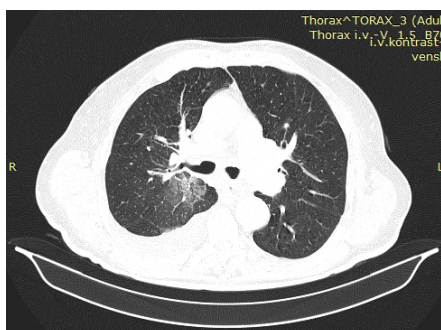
Chest CT in lung window at the same time revealed ground glass opacities in posterior segment of right upper lobe and superior segment of right lower lobe.
